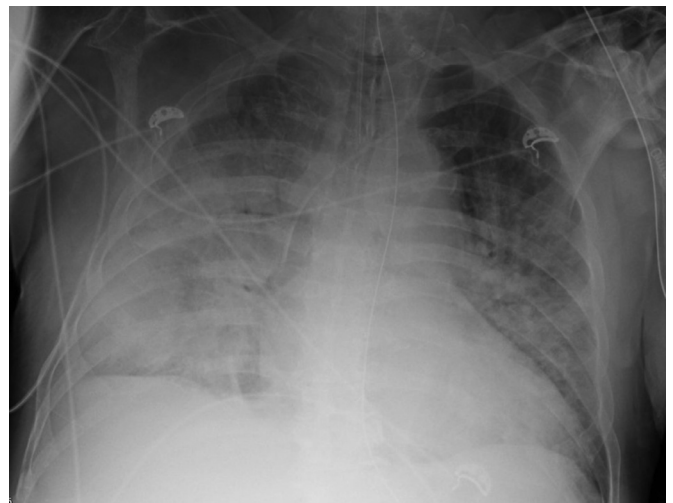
Chest x-ray shows diffuse pulmonary edema bilaterally as demonstrated by opacification of both lung fields in case 3.
